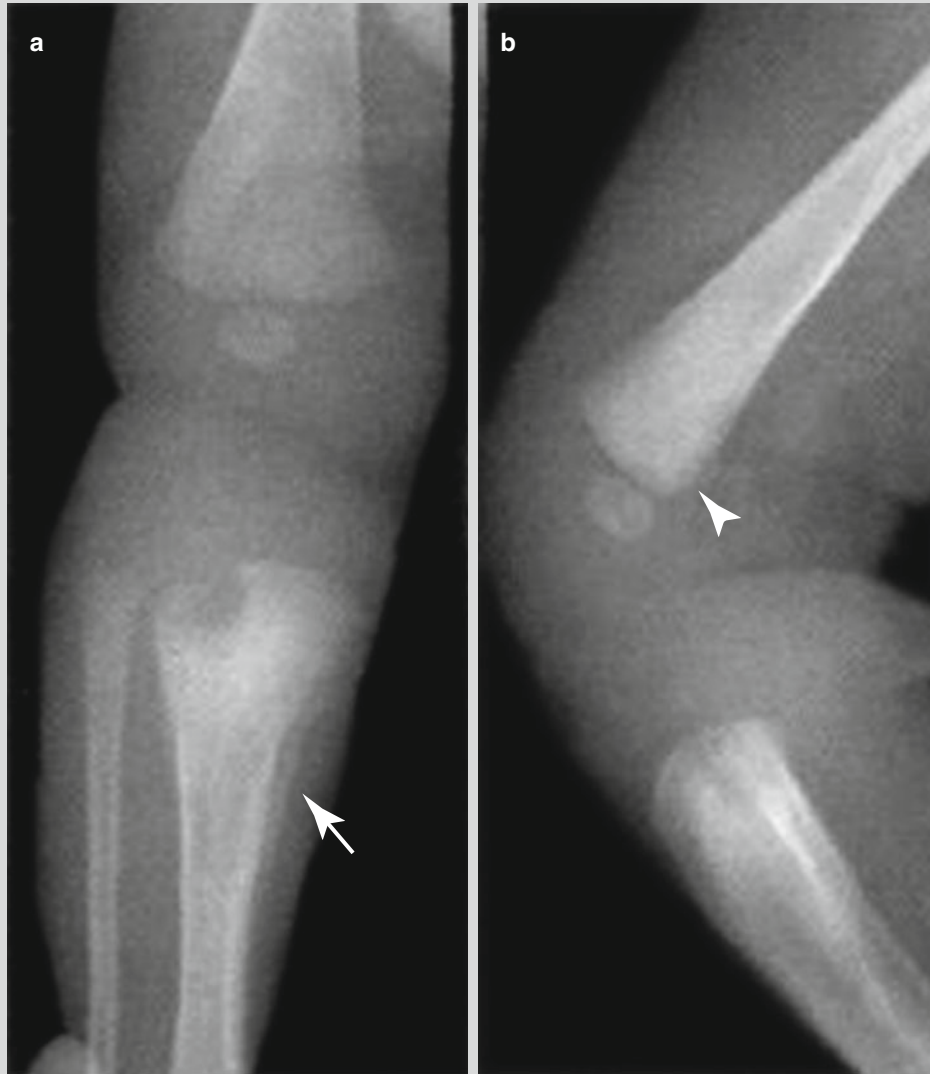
Syphilitic osteomyelitis complicated by metaphysitis and periostitis. (a) Posterior-anterior and lateral X-rays demonstrate worm-eaten-like bone destruction at the left superior tibia, with surrounding high-density area and neighboring periosteal
